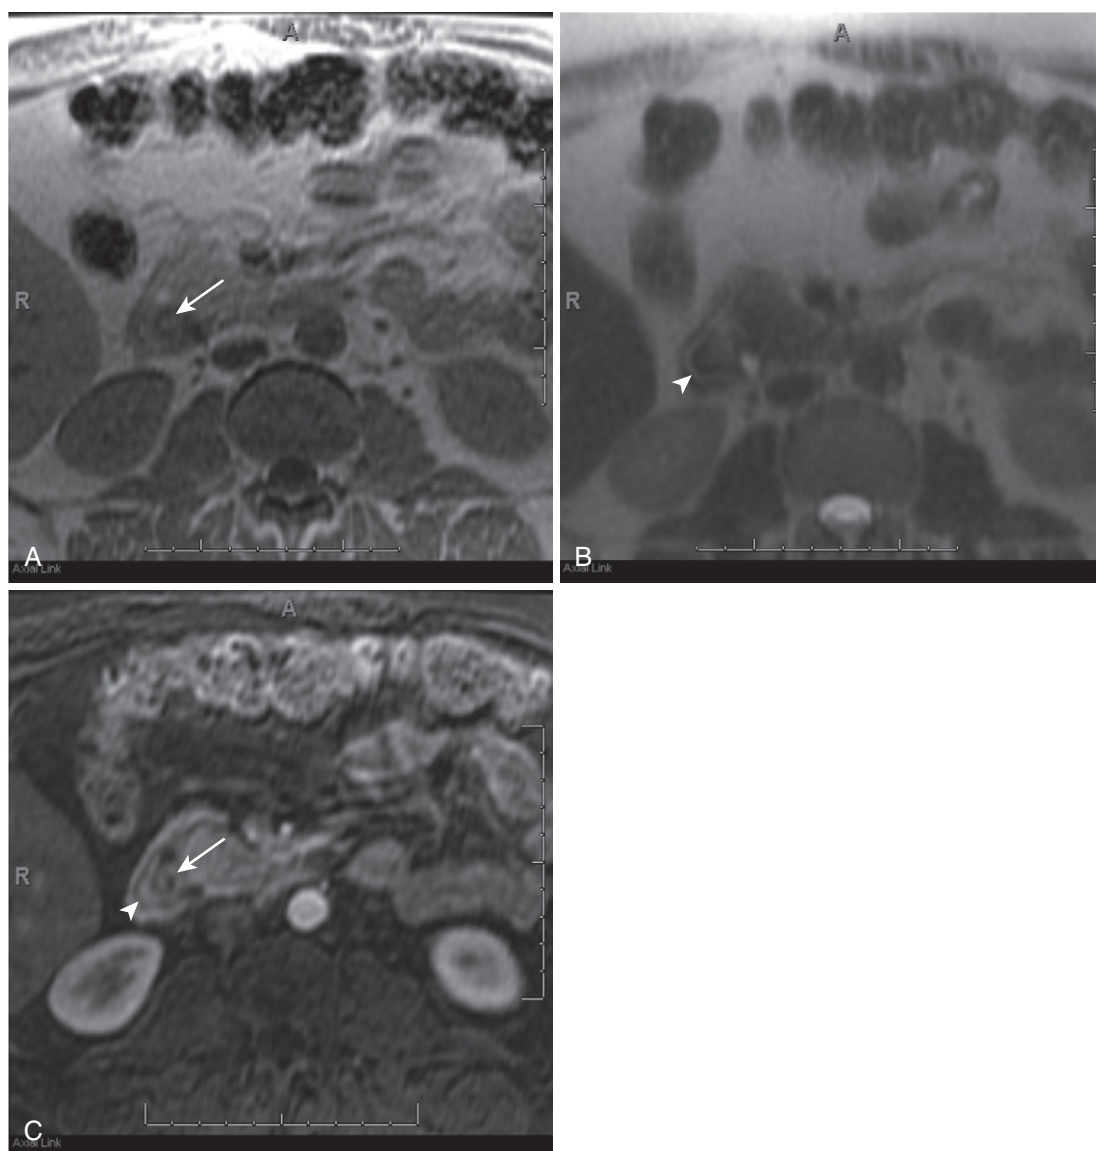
Annular pancreas. T1-weighted in-phase (A), T2-weighted (B), and fat-suppressed T1-weighted postcontrast (C) images demonstrate pancreas and aberrant duct of Santorini (*arrowhead*) encircling the duodenum (*arrow*) in this patient with annular pancreas.
